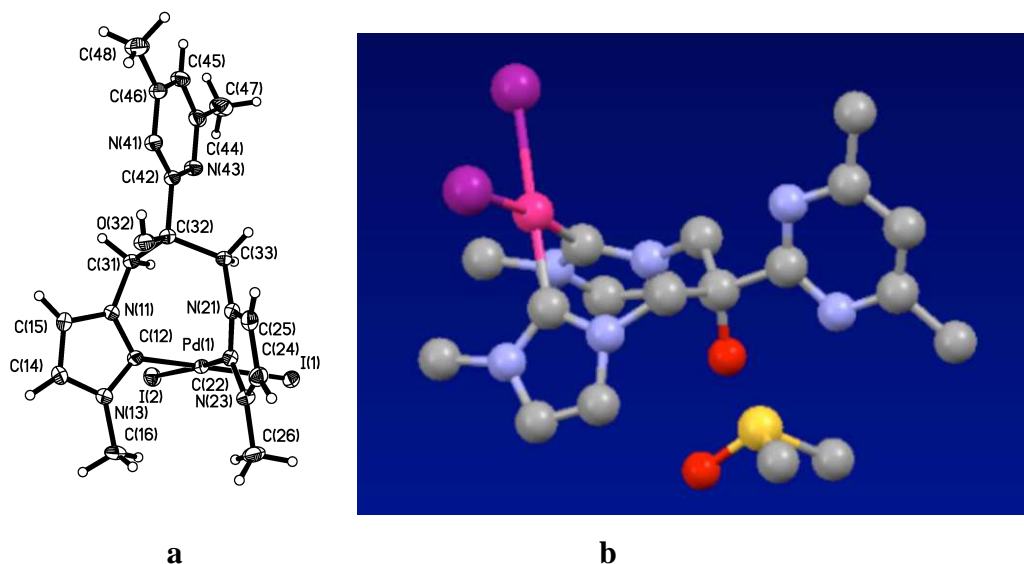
X-ray structure of complex 3.25 (a: Thermal ellipsoid plot drawn at the 50% probability level; b: The hydrogen atoms are omitted for clarity reasons).
